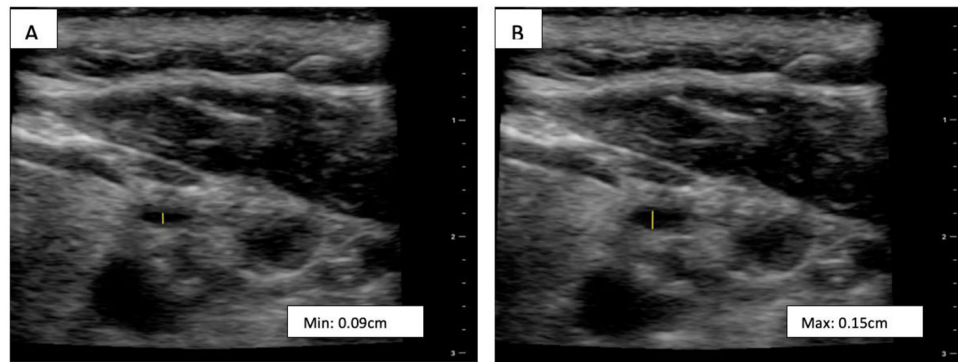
Ultrasound images of the internal jugular vein.
